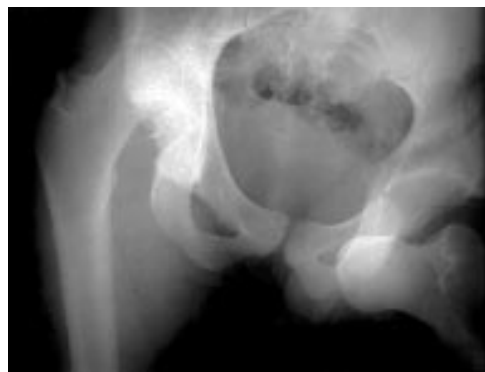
Radiograph of the pelvis and both hip joints showing an anterior dislocation of the left hip and a posterior dislocation of the right hip.
